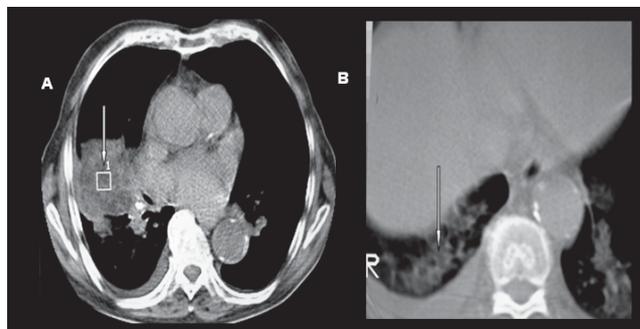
Thorax CT findings, characteristic of lipoid pneumonia.
